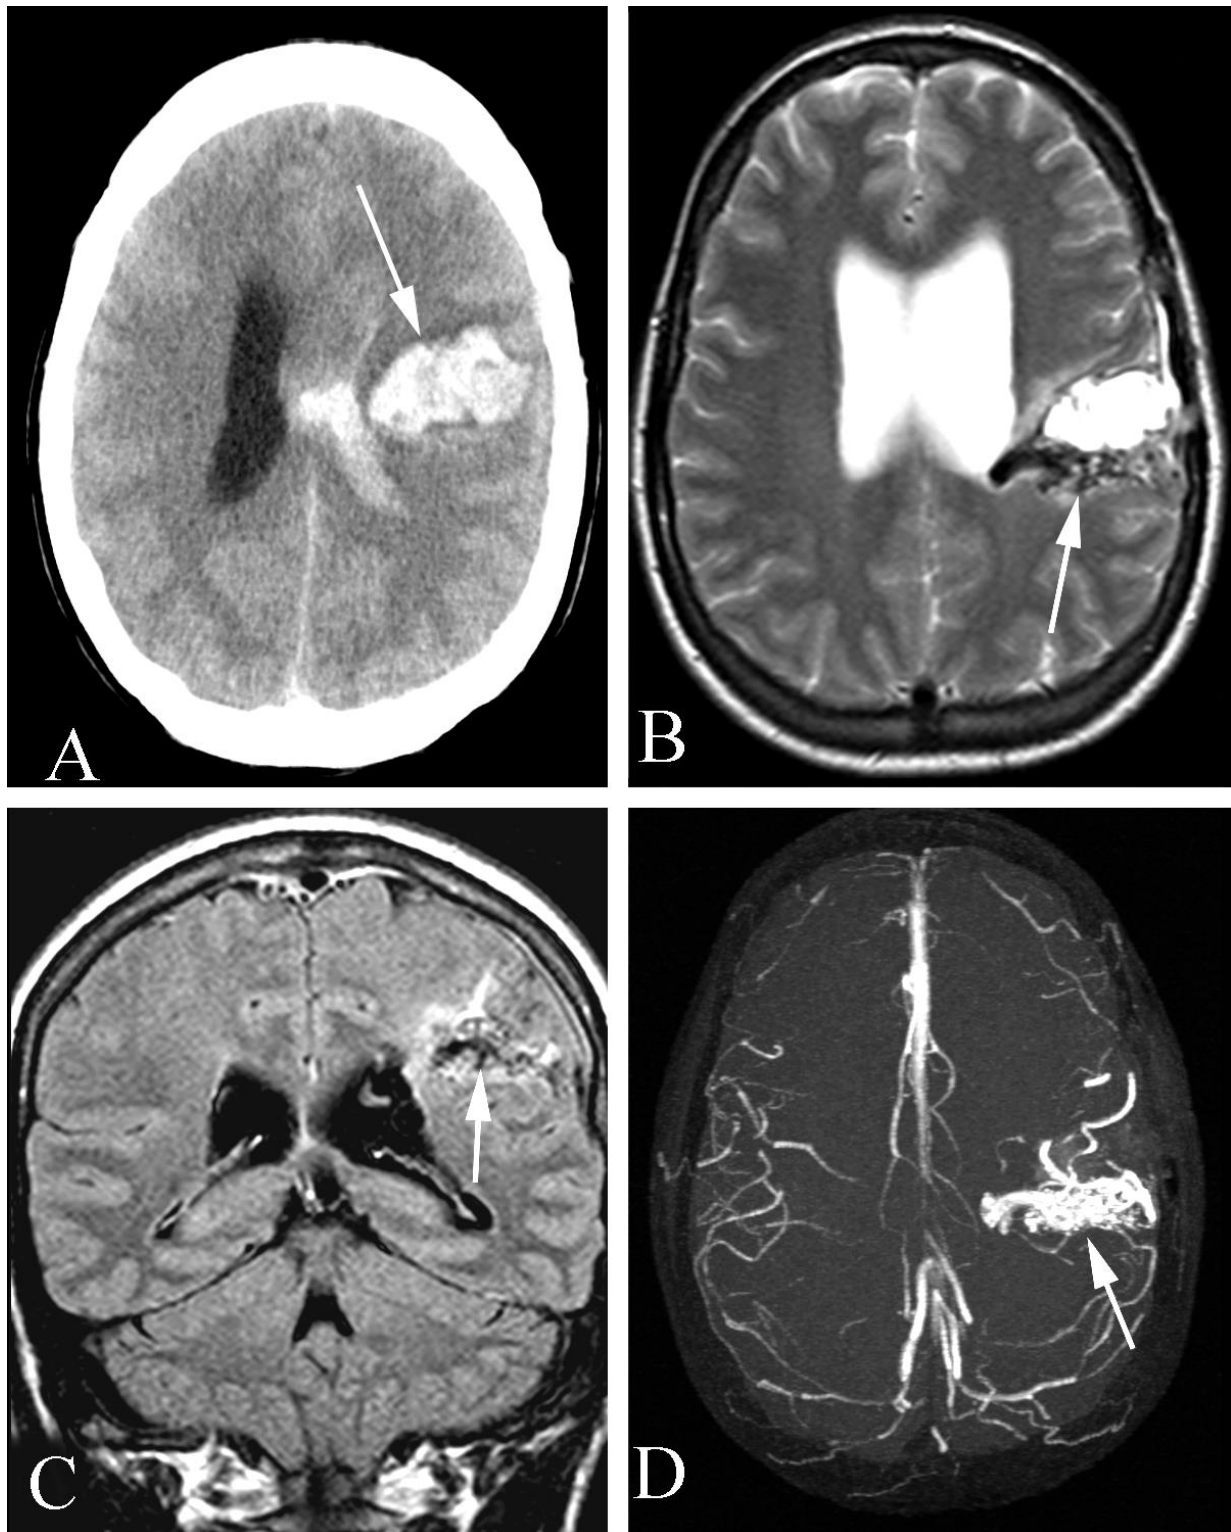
Intraparenchymal and intraventricular hematoma secondary to an intracranial arteriovenous malformation in a 45 year old woman with headache and new onset of left facial droop. A. Axial unenhanced CT demonstrates a left frontal lobe hematoma (arrow) as well as intraventricular hemorrhage. B. An axial T2 weighted MR study demonstrates the hematoma with abnormal vessels along the posterior margin (arrow). C. Coronal T1 weighted postcontrast MR study shows a complex “salt-and-pepper” appearance of the lesion. D. Axial MR angiogram demonstrates multiple abnormal vessels (arrow).
